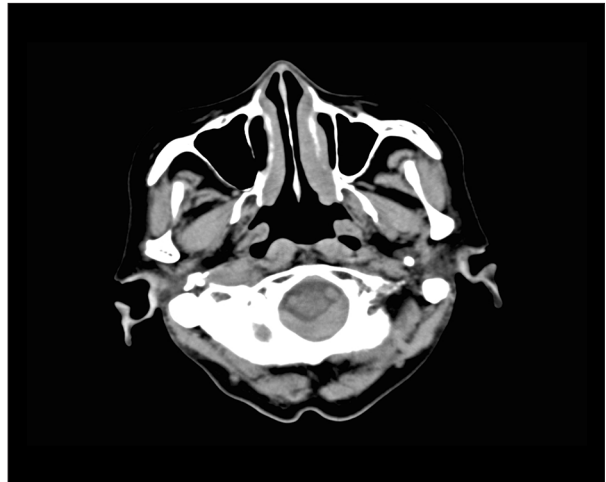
CT images of the sinus showed no findings compatible with sinusitis.
